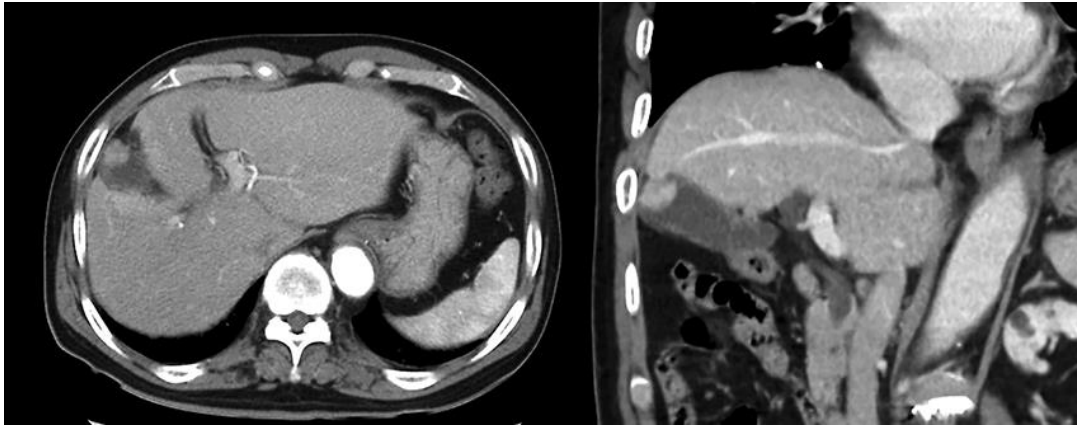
Preoperative abdominal CT findings. Abdominal enhanced computed tomography showed the tumor in the gallbladder. The tumor in the gallbladder did not extend beyond the liver and serosa, indicating Hinf0 and S0 if the tumor is gallbladder carcinoma.
